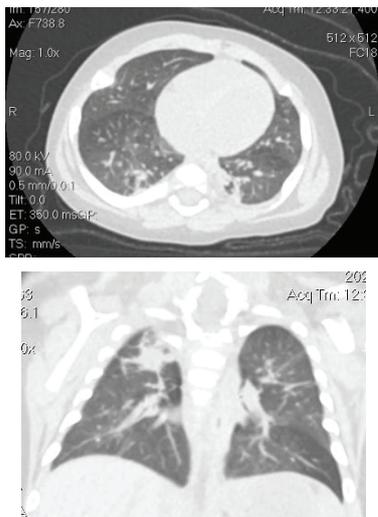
CT scan with contrast dated 22.07.21
